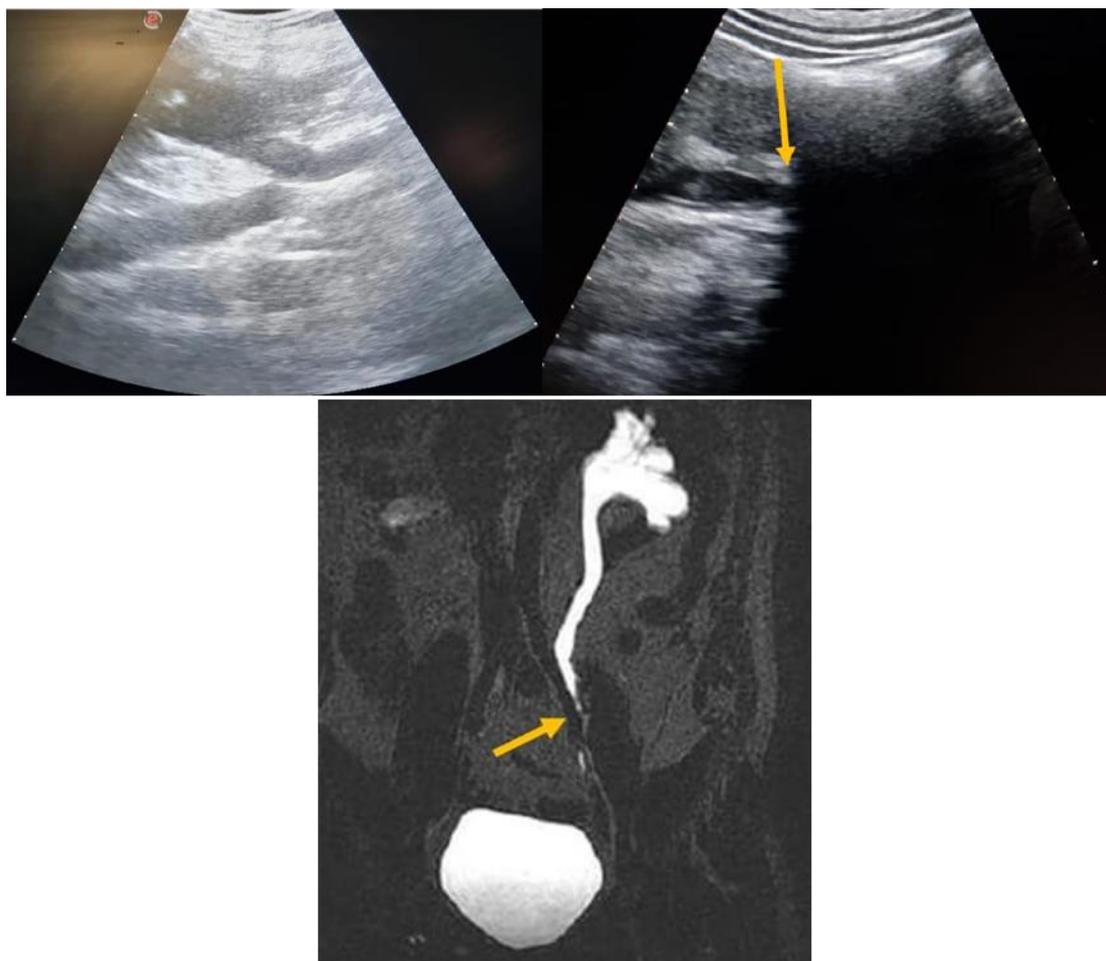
(A), (B) Grey scale ultrasound image shows ballooning of right renal pelvis & right moderate hydronephrosis and mild left hydronephrosis.
